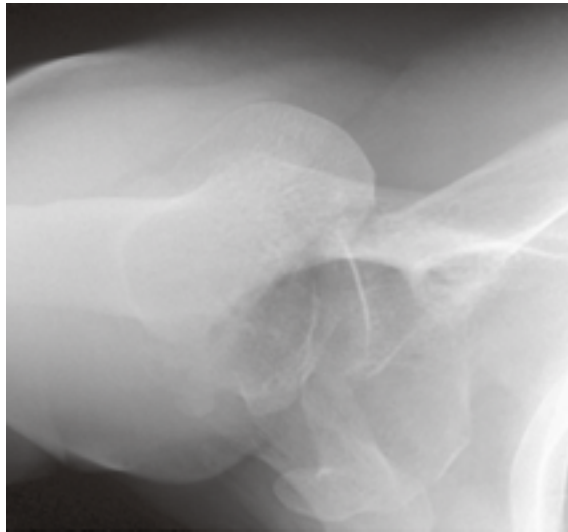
Axillary radiograph shows a posteriorly-displaced anatomical head behind the glenoid.
